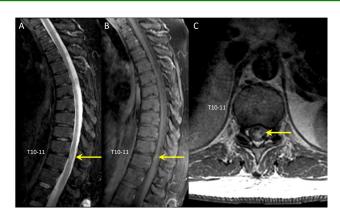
A) Sagittal T2 FLAIR image. Residual mild high T2 signal at T10-11 cord (arrow). Note that the cranial and caudal extents of cord T2 hyperintensity have significantly decreased.
